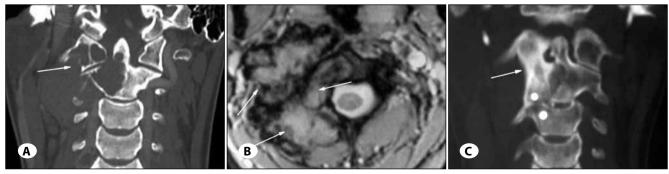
A) Coronal plane computed tomography (CT) image showing an osteolytic lesion of the C1 right lateral mass and the C2 vertebral body (arrow). B) Lobulated high-signal intensity mass on T2-weighted magnetic resonance imaging (arrow). C) CT image taken 11 years after surgery showed solid bone fusion in the C1–3 region (arrow).
